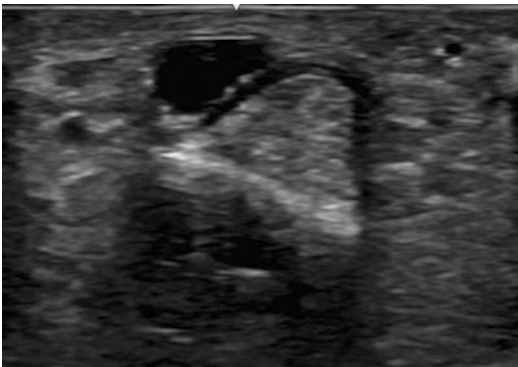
A2 pulley ganglion in a transverse ultrasound plane
